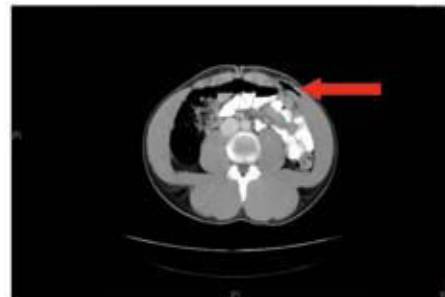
Abdominopelvic CT scan: subcutaneous emphysema extending from the left scrotum to the upper abdominal wall, between the left anterior rectus abdominis and the left lateral abdominal muscles. Absence of free intraperitoneal fluid.
